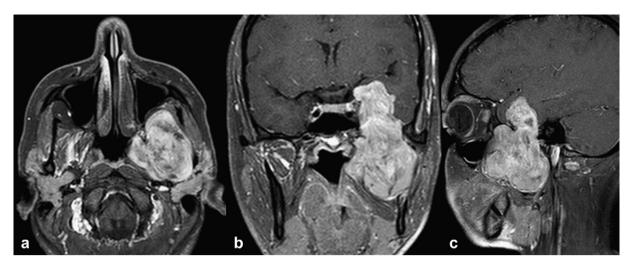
Pre-operative T2-weighted MRI in axial (a), coronal (b) and sagittal (c) planes showing tumour extension and parapharyngeal space involvement.
